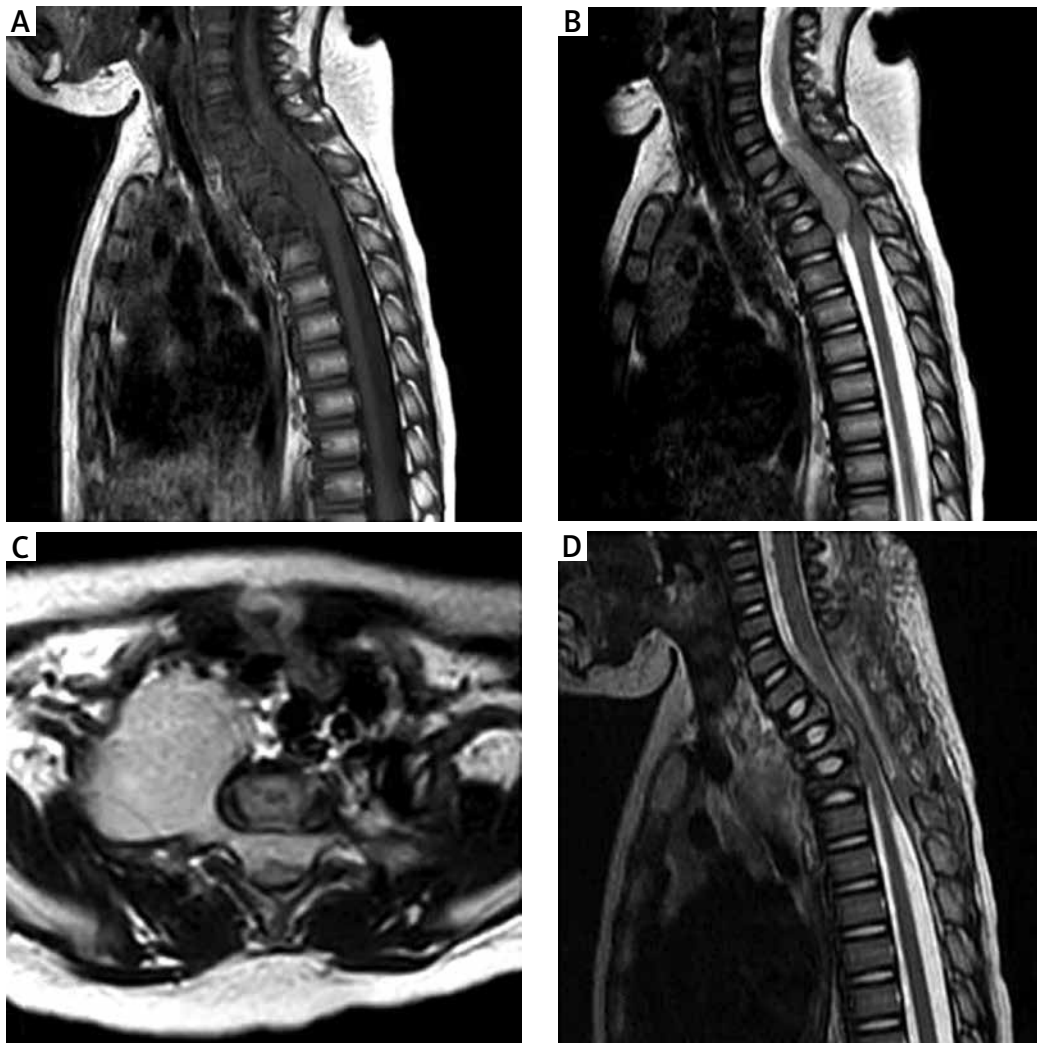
Preoperative MR imaging. A) Sagittal T1-weighted MRI; and B) Sagittal T2-weighted MRI shows a space-occupying lesion at the T1-T3 level. C) Axial T2-weighted MRI shows the extraspinal extension of the tumour through the neural foramen, forming a dumbbell-shaped mass. D) Post-operative sagittal T2-weighted MRI shows the resection of the intraspinal tumour part.
